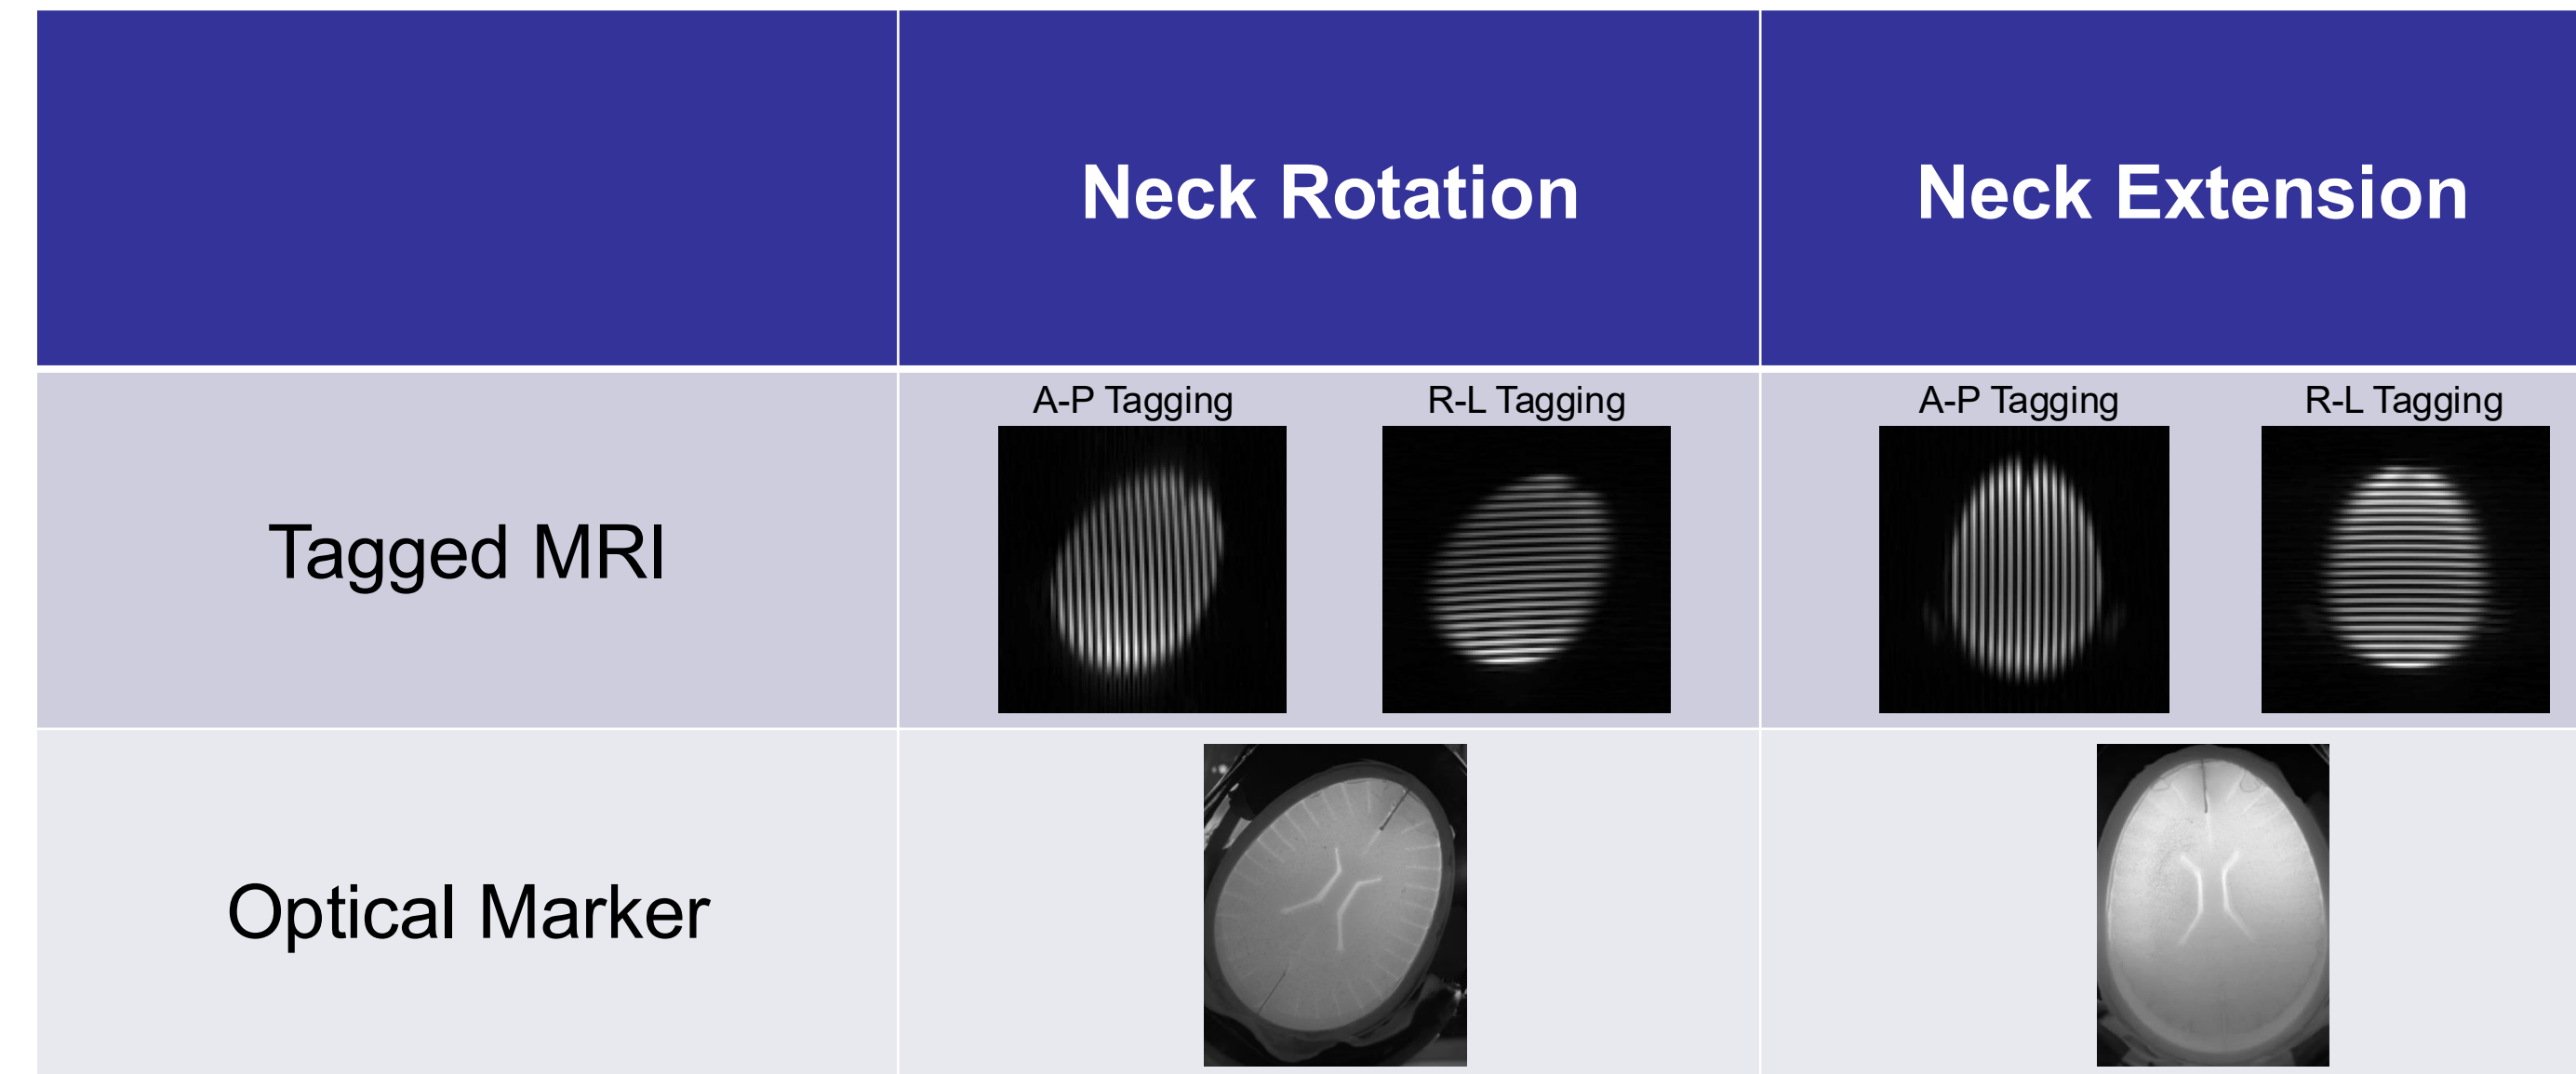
Tagged MRI and optical marker images acquired during neck rotation and neck extension. A–P: anterior–posterior; R–L: right–left.
